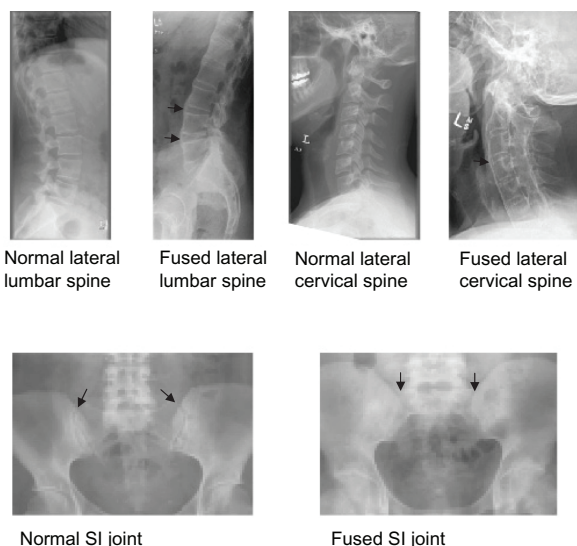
Axial inflammation in AS. In normal lumbar and cervical spine x-rays clear delineation of the intervertebral spaces is evident. However in severely affected fused spinal x-rays extensive bridging across the vertebrae is evident (arrows). In the sacroiliac (SI) joints in normal subjects the joint space is clearly visible (arrows) but in severely affected cases, fusion is evident with blurring of the joint space (arrows). Images courtesy of Linda Bradbury at the University of Queensland Diamantina Institute.
